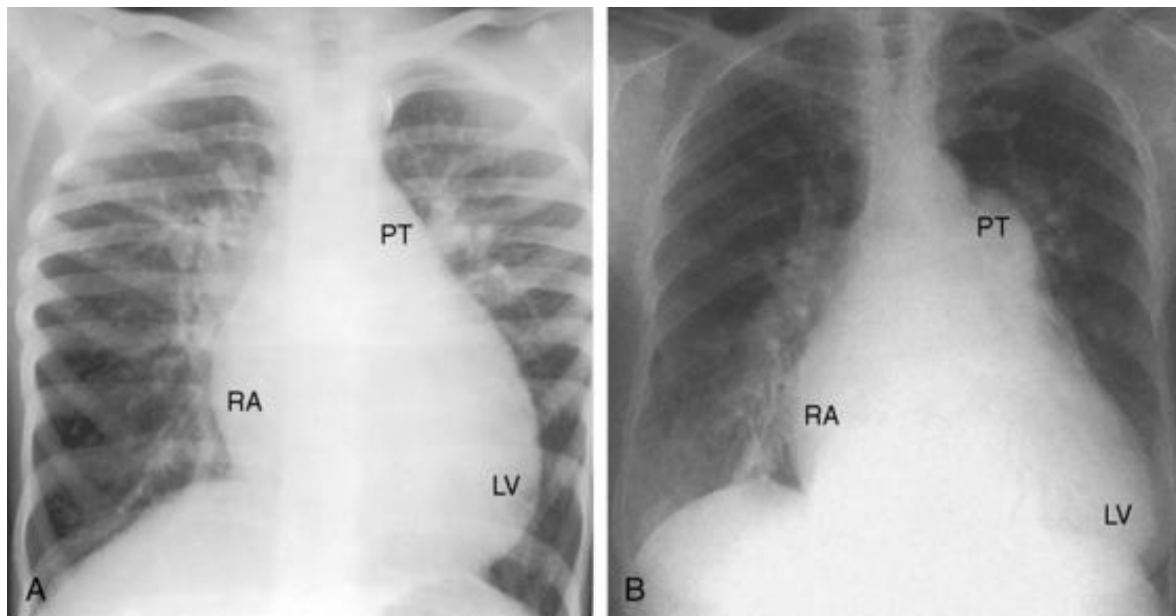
X-rays of two patients with perimembranous ventricular septal defects, 60 years apart in age. A, A 5-year-old kid with a moderately restrictive ventricular septal defect, a 2.6-to-1 left-to-right shunt, and a pulmonary artery pressure of 43/13 mm Hg. An enlarged left ventricle (LV) occupies the apex, and a prominent right atrium occupies the right lower cardiac border. Pulmonary arterial vascularity is increased, the pulmonary trunk (PT) is moderately dilated, an enlarged left ventricle (LV) occupies the apex, and a prominent right atrium occupies the right lower cardiac border. B, A moderately restrictive perimembranous ventricular septal defect, a 2.7 to 1 left-to-right shunt, and a pulmonary artery pressure of 55/32 mm Hg were present in the 65-year-old woman. An enlarged left ventricle (LV) occupies the apex, and a prominent right atrium (RA) occupies the lower right cardiac border. Pulmonary arterial vascularity is increased, the pulmonary trunk (PT) is markedly dilated, an enlarged left ventricle (LV) occupies the apex, and an enlarged left ventricle (LV) occupies the apex [14]
